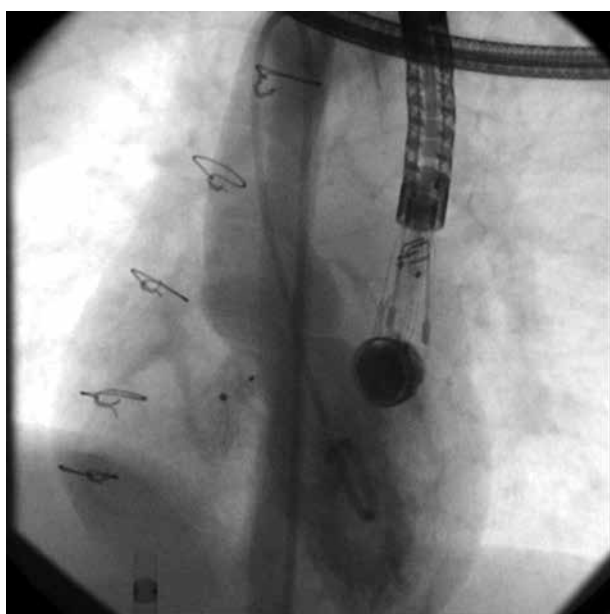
LAO 30 projection. Left ventriculography. Gerbode-like post-surgical VSD closed with ADO II AS. Still visible foam of radiographic contrast from left ventricle to right atrium
